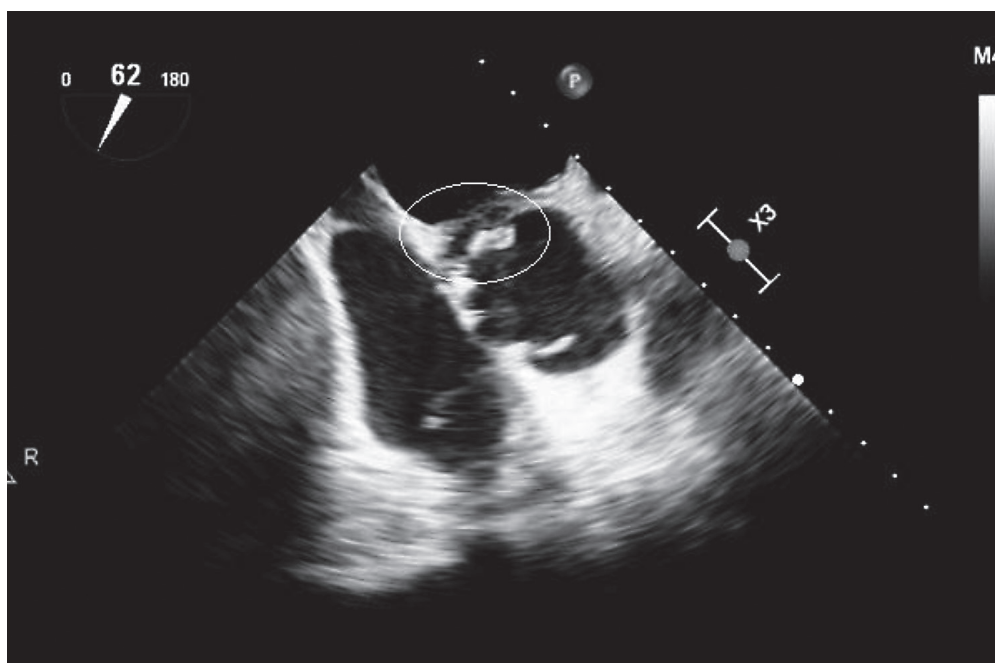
Transesophageal echocardiography revealed the presence of a paravalvular abscess around the aortic valve, along with vegetations.
